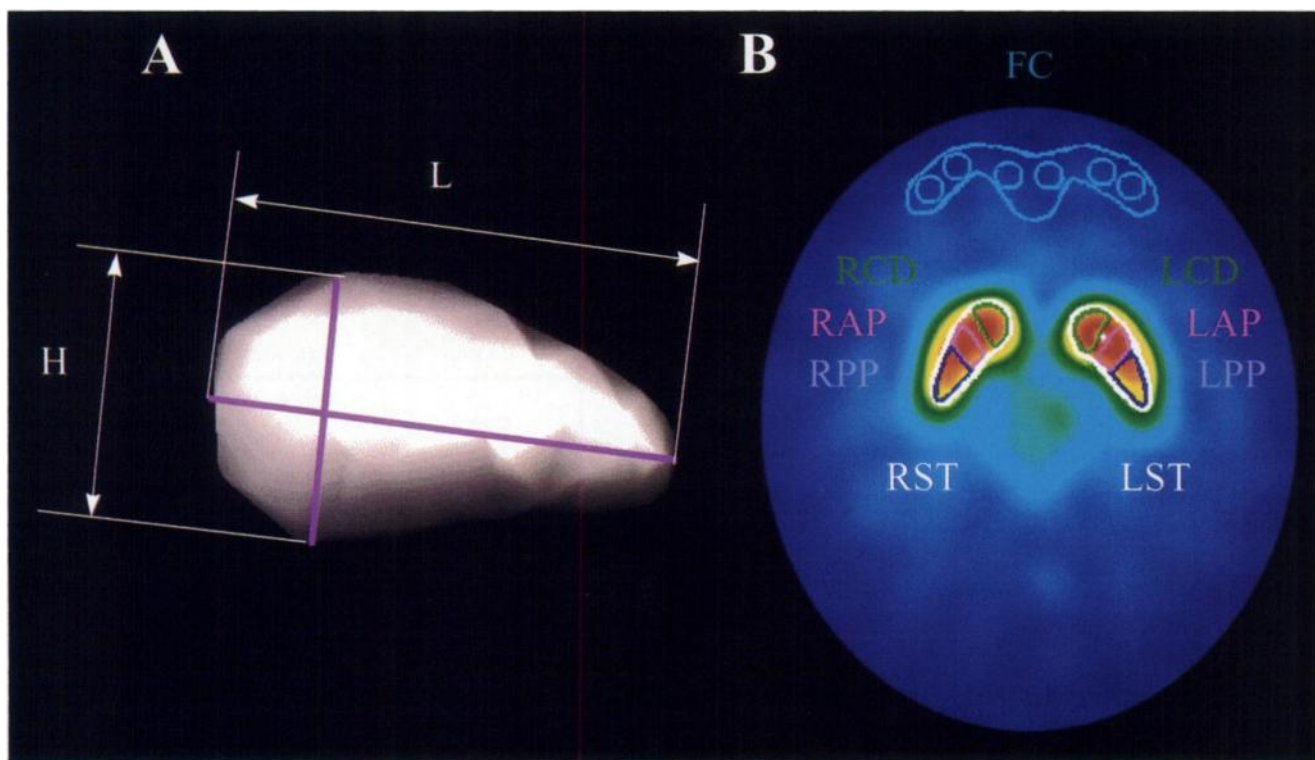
(A) Three-dimensional surface display of left striatum shows typical vertical height (H) of caudate head and length (L) of long axis of striatum (lateral oblique view). (B) Transverse ^{123}I - β -CIT SPECT image shows typical ROI sets. R = right; L = left; FC = frontal cortex; ST = striatum; CD = caudate; AP = anterior putamen; PP = posterior putamen.
